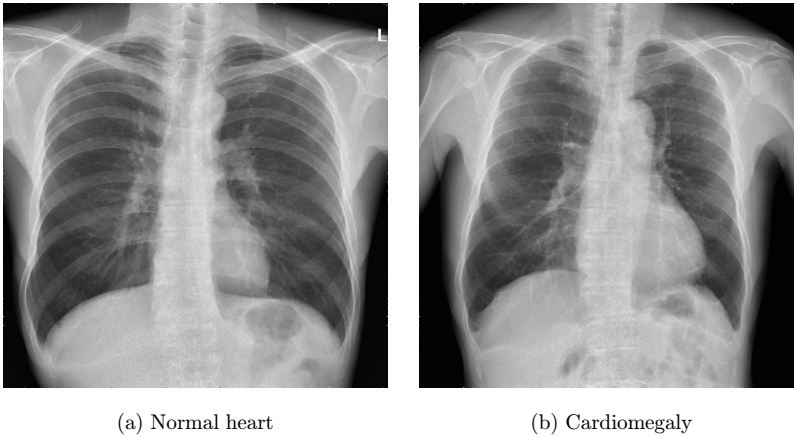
Chest X-ray images.
